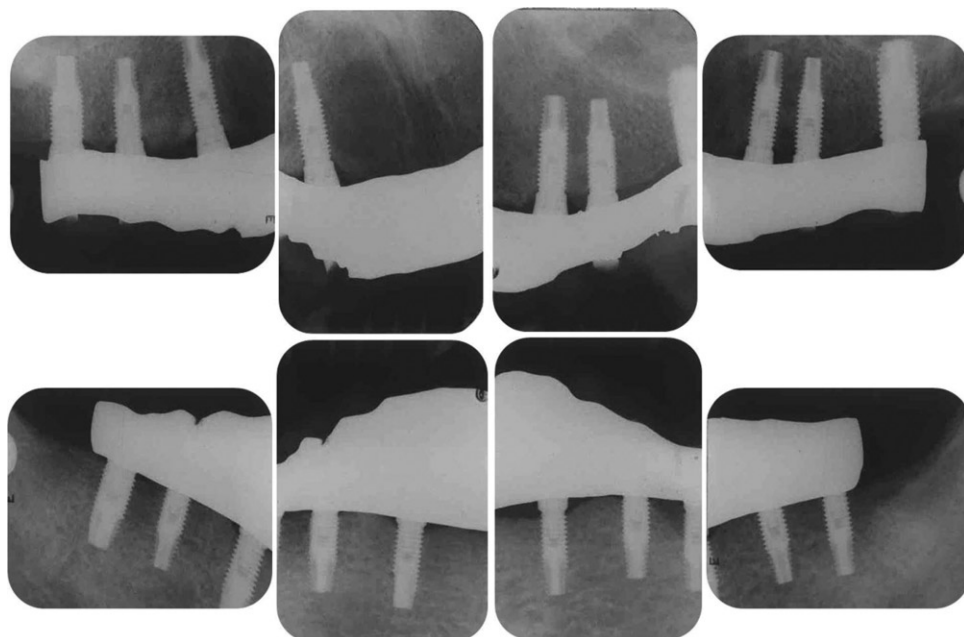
Periapical radiography at 10 months after delivery of prosthesis.
